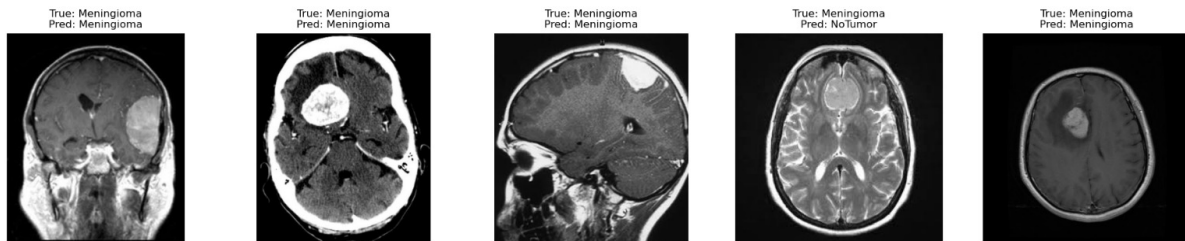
Visualization of MRI images for a class of meningiomas with model predictions.
